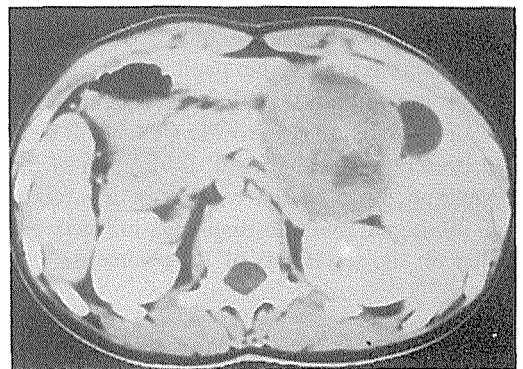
Contrast-enhanced CT scan with inhomogeneous opacification of tumor with enhanced capsule of the tumor.
